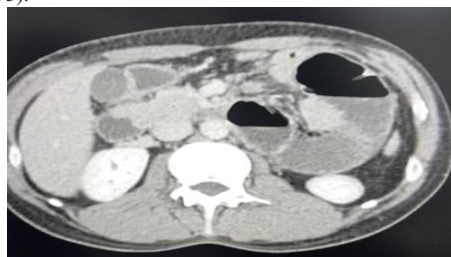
Axial contrast-enhanced CT image showing a cluster of dilated jejunal loops in the left paraduodenal region with normal wall thickness and enhancement.
